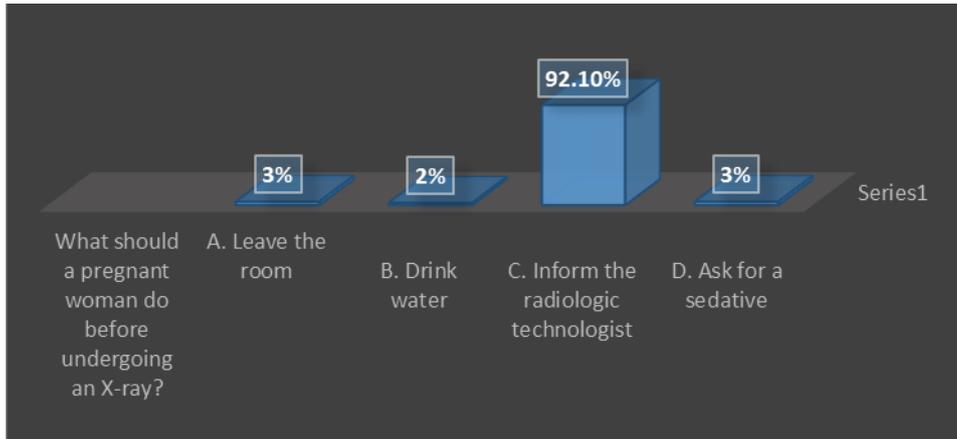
Pregnant woman do before undergoing x-ray
